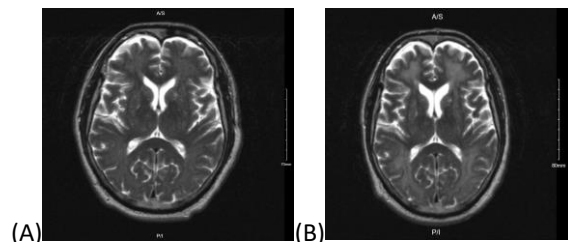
T2 Axial View: (A) Initial MRI with nonspecific white matter changes; (B) Repeat MRI with extensive diffuse bihemispheric confluent and symmetric white matter T2 hyperintensities.
